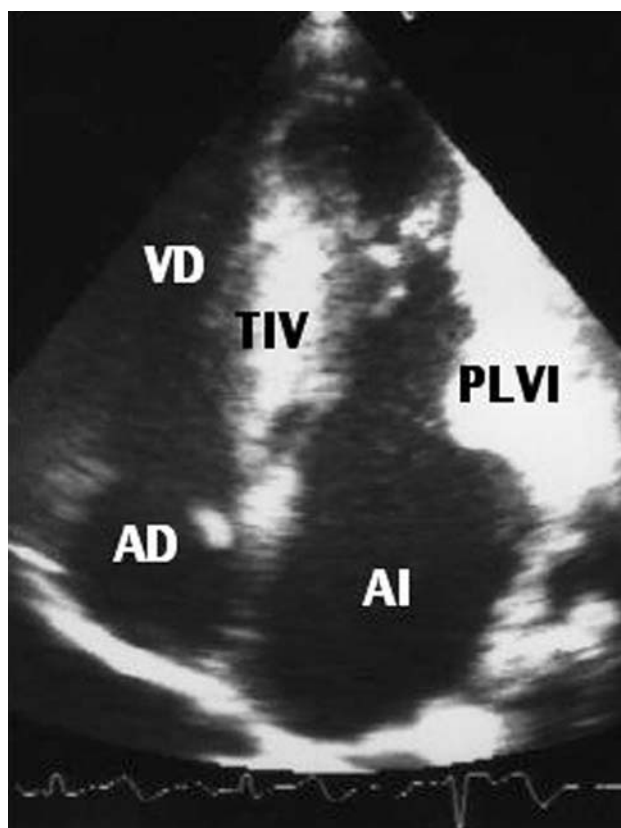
Apical 4-chamber view with echo-contrast opacification of the intraventricular septum (IVS), and left ventricular free wall (LVFW). RV indicates right ventricle; RA, right atrium; LA, left atrium.
